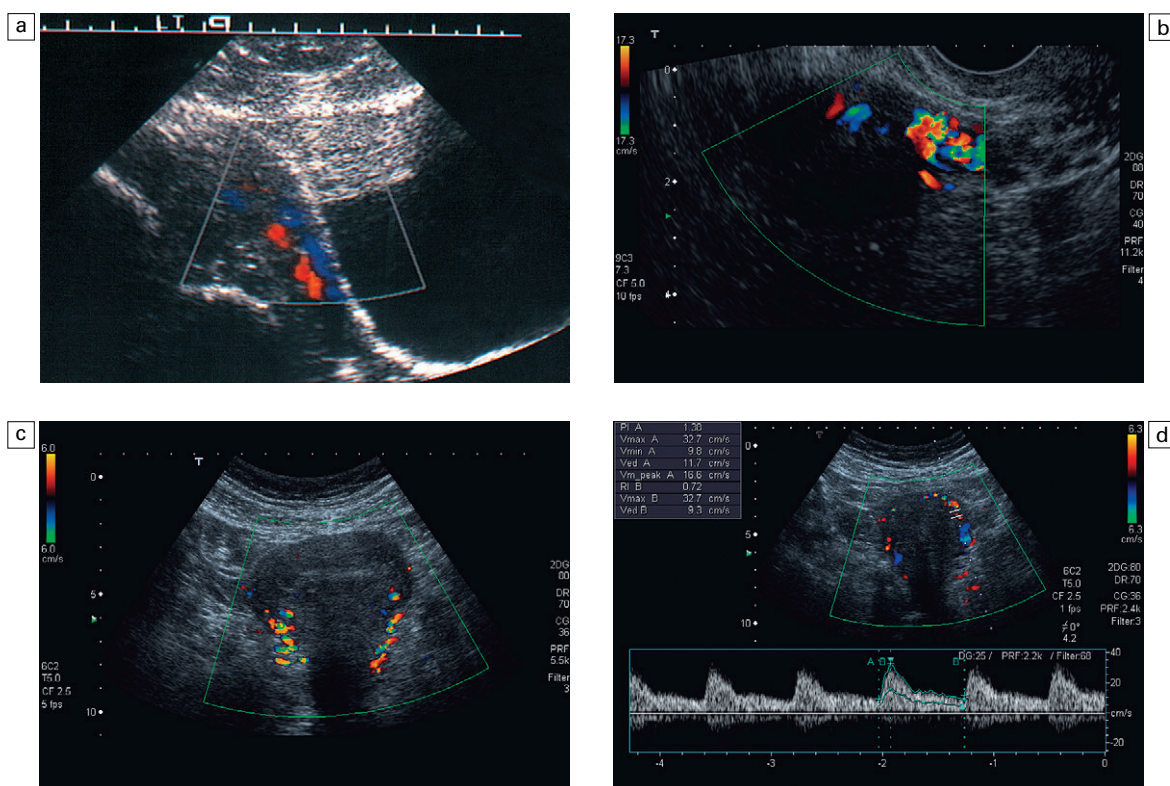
(a) Sagittal transabdominal scan along the left margin of the uterus demonstrating the uterine artery and vein. (b) Sagittal transvaginal scan along the margin of the uterus demonstrating the uterine vessels. (c) Coronal transabdominal scan demonstrating uterine arteries. (d) Spectral Doppler from uterine artery demonstrating automatic calculation of indices.
